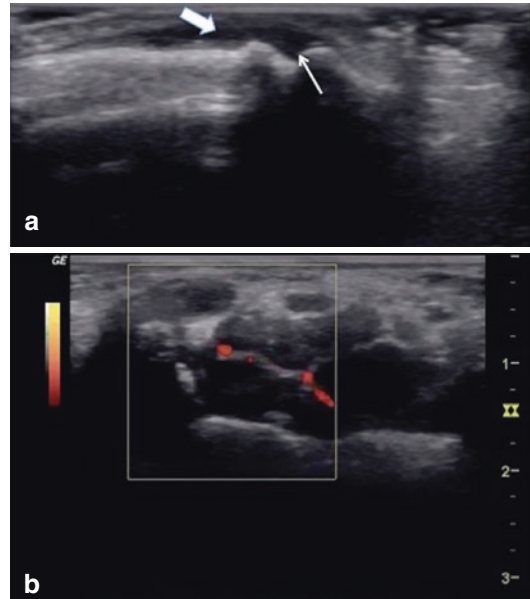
Ultrasonographic findings in a patient with rheumatoid arthritis. (a) Edema around the proximal interphalangeal joint. Arrow: joint space. Block arrow: tissue edema. (b) Increased Doppler activity around the wrist
